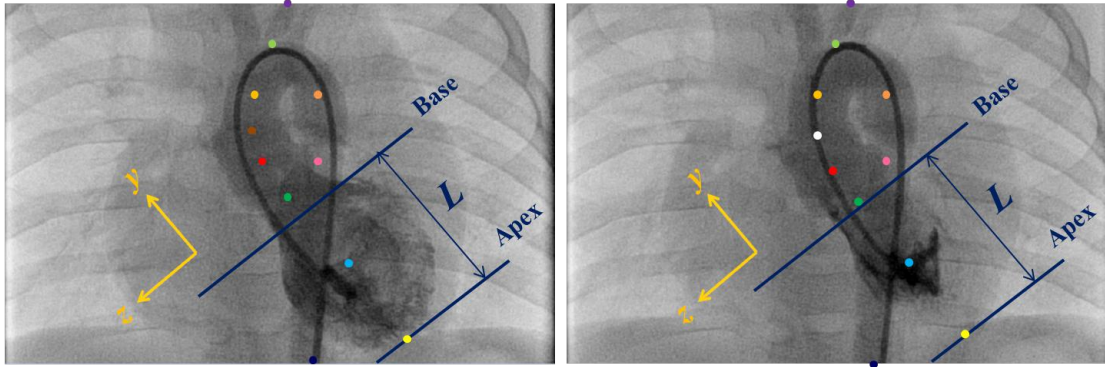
Measurement length of translation motion from CT image (left: at maximum volume, right; at minimum volume)
